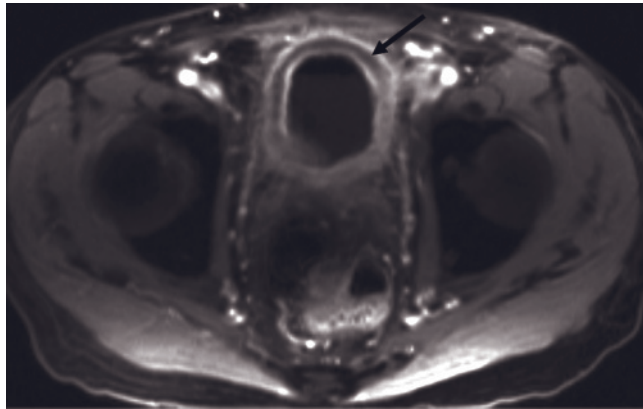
Bladder inflammation. Sagittal T1-weighted immediate postgadolinium SGE image (a) in a patient with a suprapubic catheter (black arrow). Substantial enhancement of the bladder wall is demonstrated (small arrows, a). T1-weighted SGE (b), immediate postgadolinium SGE (c), and sagittal 5-min postgadolinium SGE (d) images in a second patient with mild inflammatory cystitis. The bladder wall is irregularly thickened (arrows, b), with minimal enhancement after contrast administration (arrows, c, d). Ninety-second postgadolinium SGE (e) and T1-weighted postgadolinium fat-suppressed spin-echo (f) images in a third patient with inflammation secondary to infection. Diffuse bladder wall thickening is present (arrows, f), and a large gadolinium-containing diverticulum (arrows, e) is identified arising from the right aspect of the bladder. A small high-signal-intensity tract represents the communication between the bladder and the diverticulum (short arrow, f). Ninety-second postgadolinium fat-suppressed SGE image (g) in a fourth patient who had undergone intraperitoneal chemotherapy. Increased enhancement of the serosal surface of the bladder (small arrows, g) is present, which represents chemical peritonitis. Transverse T2-weighted
